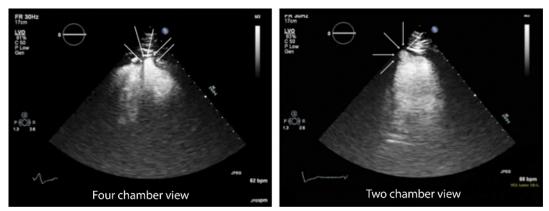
A 46-year-old man from southern Mexico with no known coronary artery disease (patent coronary arteries on recent coronary angiography) presented to the hospital with recurrent episodes of ventricular tachycardia. His medical history was notable for sick sinus syndrome, and he recently underwent placement of an implantable cardioverter defibrillator. A contrast-enhanced echocardiogram performed at time of admission demonstrated global hypokinesis with dyskinesia of the apical cap of the left ventricle and a focal finger-like apical aneurysm. Two representative contrast-enhanced views are demonstrated global hypokinesis with dyskinesis of the apical aneurysm. Dynamic imaging demonstrated global hypokinesis with dyskinesis of the apical aneurysm (Movie 1, 4 chamber cine, http://links.lww.com/CNM/A73) and near akinesis of the mid to basal inferior and lateral walls (Movie 2, short axis cine, http://links.lww.com/CNM/A74). These findings raised the question of chronic Chagas disease, as narrow-necked left ventricular apical aneurysms have been described as a distinguishing feature.^{1,2}
